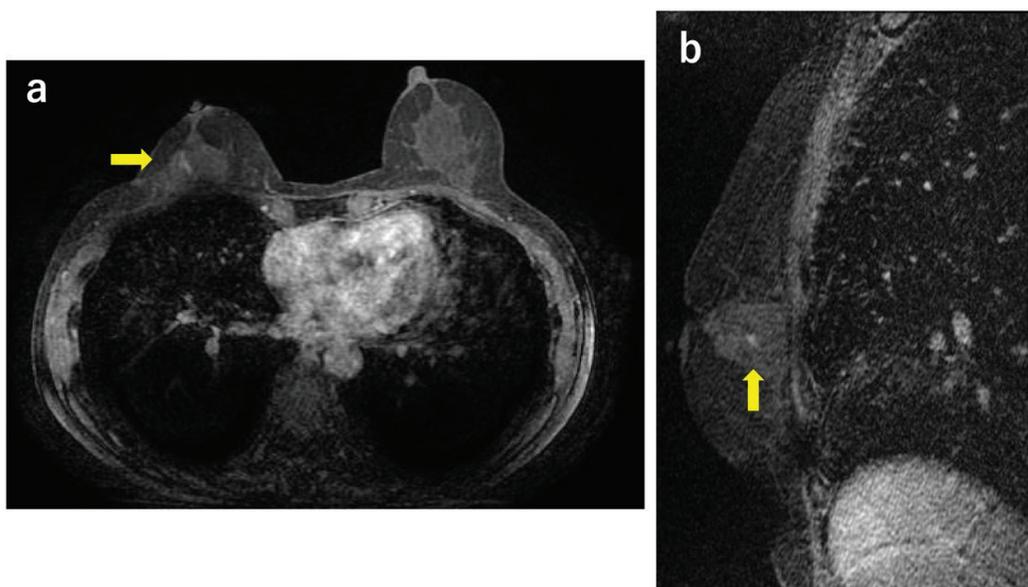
(a, b) case 10: a 67-year-old woman, a *BRCA2* pathogenic variant carrier, developed peritoneal cancer eight years after surgery and risk-reducing salpingo-oophorectomy for right ductal carcinoma *in situ*. She received chemotherapy, and subsequent magnetic resonance imaging (MRI) surveillance showed a category 4 non-mass enhancement with branching in the right outer quadrant. MRI-guided biopsy diagnosed ductal carcinoma *in situ*. The patient underwent right and contralateral prophylactic mastectomies
